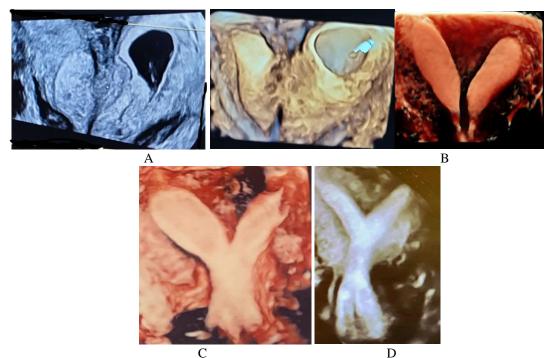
A. coronal B. 3D ultrasound images of uterine didelphys with ongoing early pregnancy (hand pointer), HD uterine Didelphys (left image) C, D. HD and 3D ultrasound images of bicornuate uterus.
